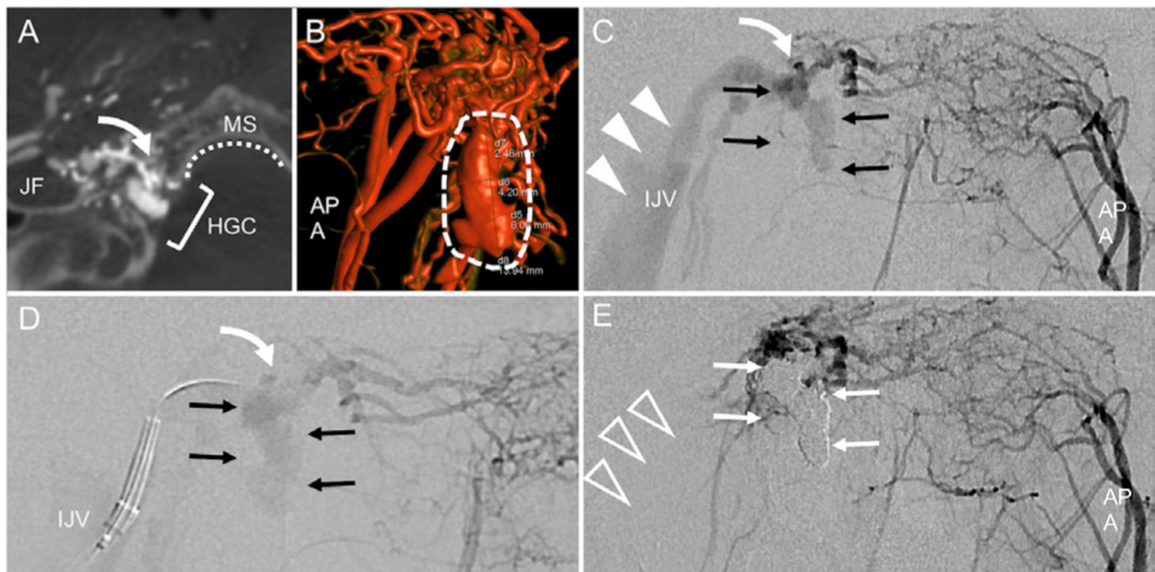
Anterior condylar vein arteriovenous fistula. Dyna-CT angiography with injection of the right ascending pharyngeal artery (APA) shows anatomy of the shunt (curved arrow) within the hypoglossal canal (HGC), adjacent to the marginal sinus (MS) and jugular foramen (JF). 3D re-formation shows that the fistulous pouch (dashed arrows) extends caudally into the MS. Panels C-E show sequential steps of arteriography-guided transvenous embolization: Water's/anteroposterior (AP) view of left APA injection shows the fistula (white curved arrow) and venous pouch (black arrows) with the ipsilateral jugular vein (IJV, white arrowheads). In D, a guide catheter is positioned in the IJV with microcatheter directed toward the fistula and pouch. From this position the fistula is embolized with coils. Postembolization left APA injection (E) shows resolution of shunting to IJV (clear arrowheads) and coil occlusion of venous pouch (white arrows).
